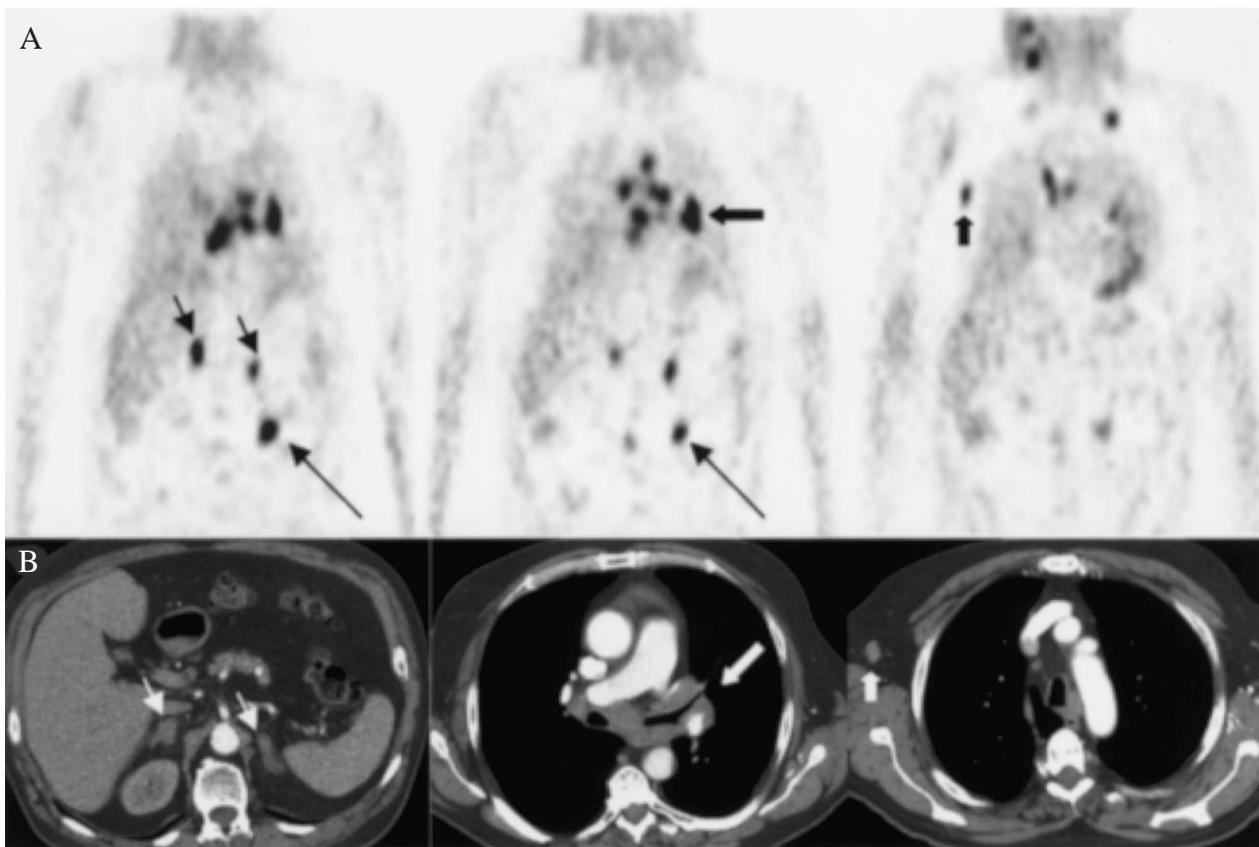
Hybrid FDG PET (A) and multislice computed tomography (CT) (B) showing a 63-year-old male patient with a squamous cell carcinoma infiltrating the left main bronchus (long fat arrows) with metastatic involvement of bilateral mediastinal, scalenic and cervical lymph nodes. Additionally, spread to the right axilla was detected (short fat arrows, right column) by the FDG investigation, this lesion could be confirmed retrospectively by CT. Also, adrenal metastases can be seen (short arrows), the caudal hot spot on the left side (long arrow) is caused by renal activity.
